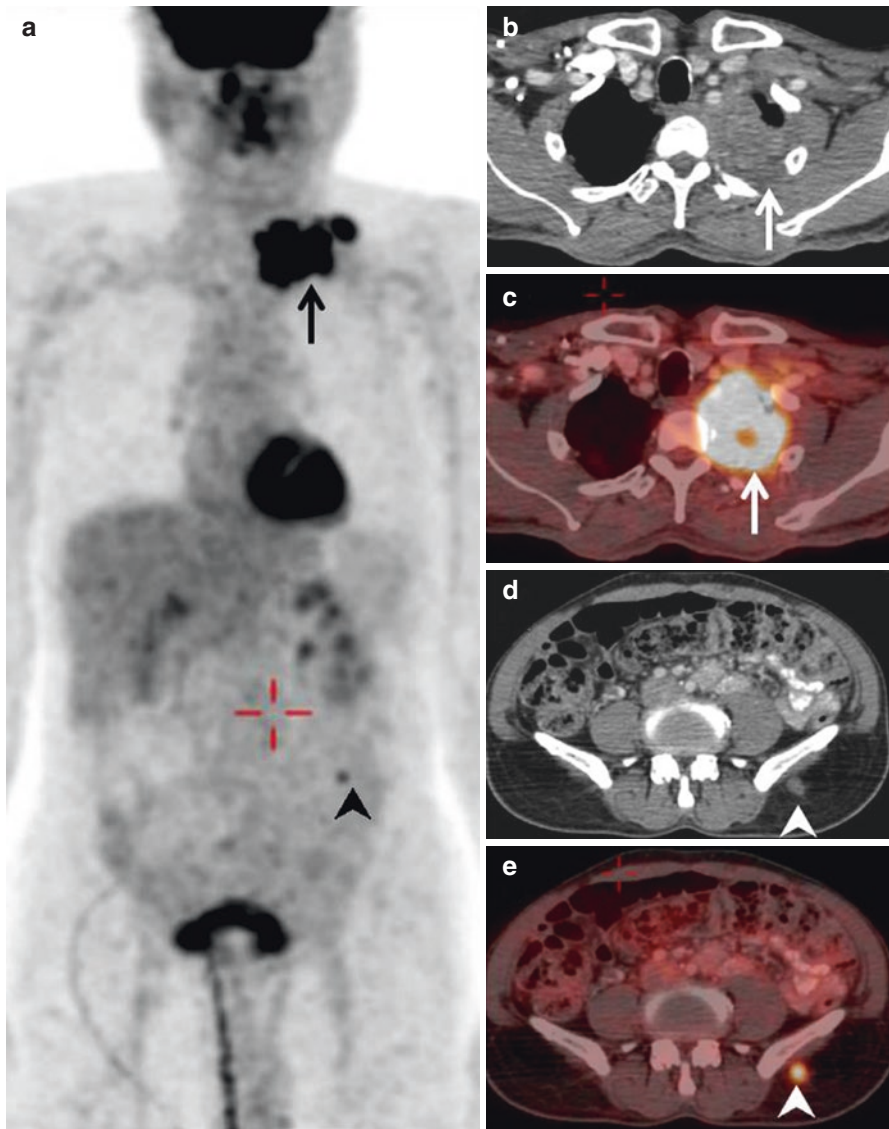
Whole body MIP image axial CT and fusion PET/CT images show a FDG-avid Pancoast tumor in the left lung apex (arrows in a–c). Focus of FDG avidity in the lower abdomen seen in the MIP image (arrowheads in a) corresponds to metastatic soft tissue deposit in the gluteal region on CT and fusion PET/CT images (arrowheads in d, e)
